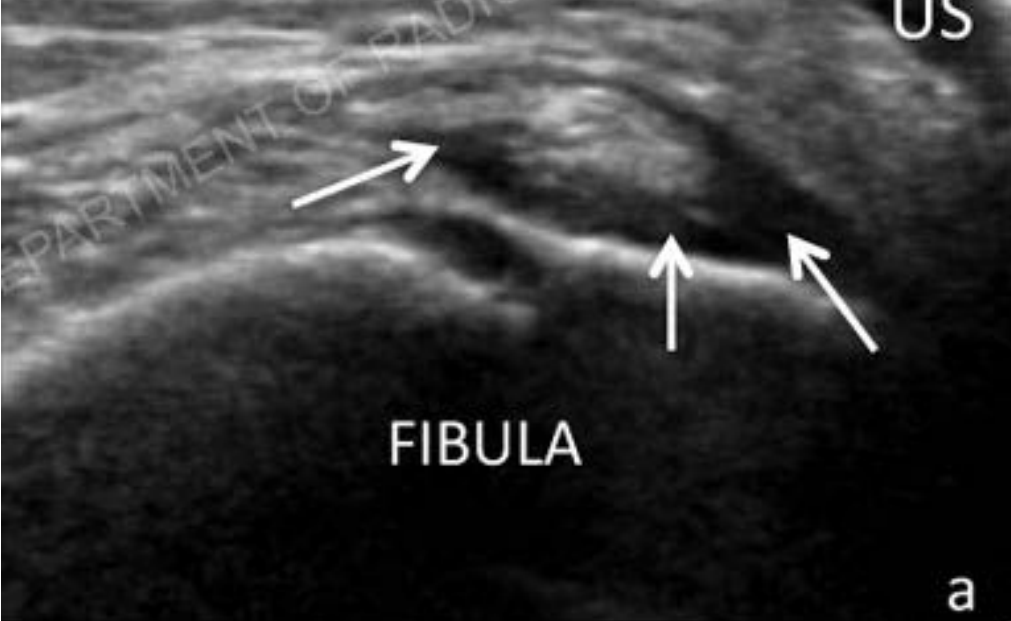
US image of the CPN (a) and corresponding axial MR images (b, c) in the same patient with CPN palsy. The scar-encased CPN is well seen on US (a) but poorly seen in the MR images (b, c, orange arrows) due to the adjacent tibiofibular screw, despite metal artifact reduction technique (c).
